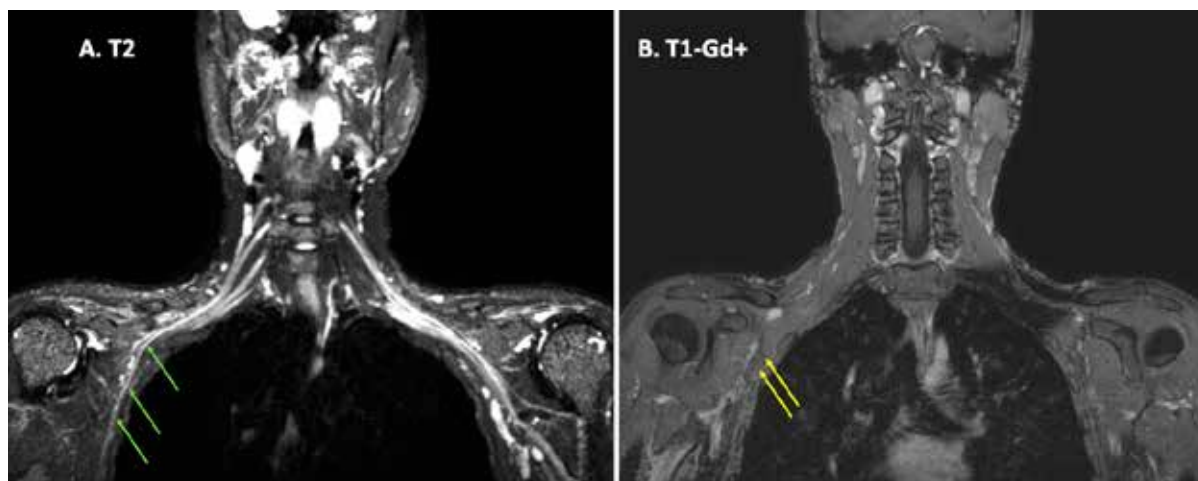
High resolution 3 Tesla Magnetic Resonance Neurography. Coronal T2-weighted STIR sequences demonstrating characteristic diffuse hyperintense signal across the right long thoracic nerve (Panel A; green arrows), without distinct gadolinium enhancement (Panel B; yellow arrows).
